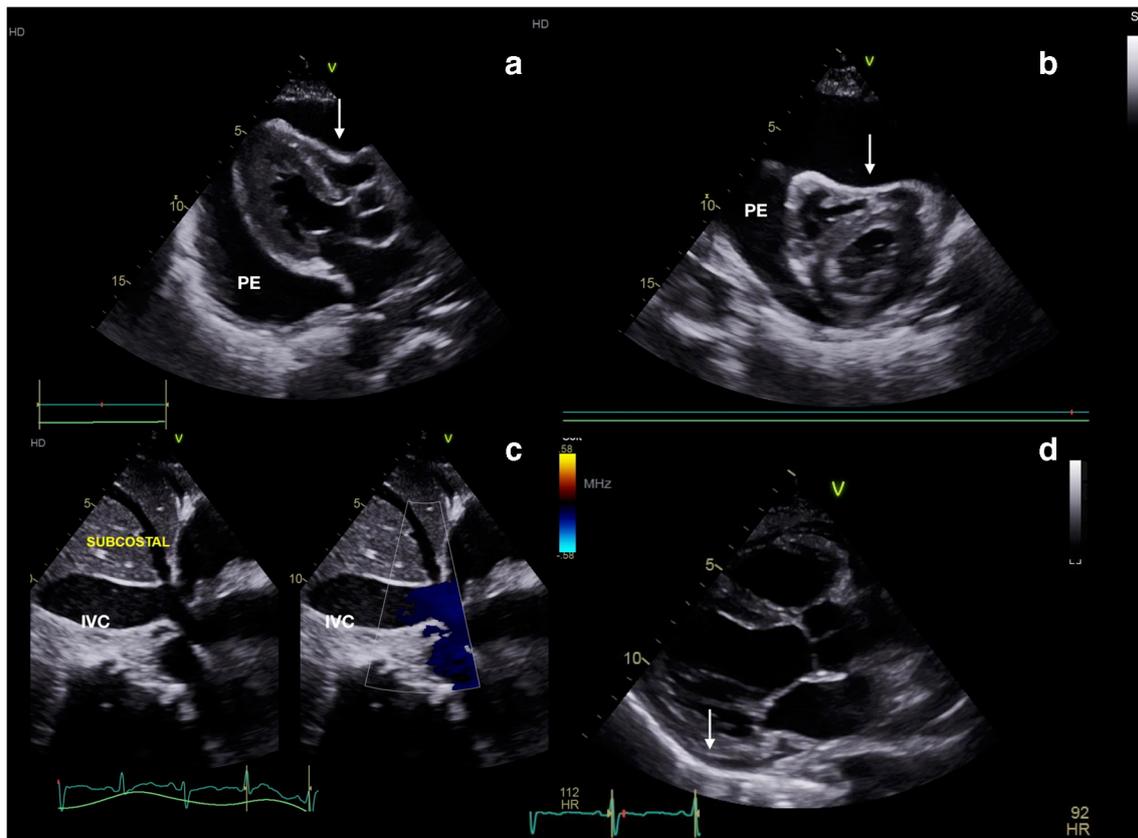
a Apical four-chamber view on 2D echocardiography with large circumferential pericardial effusion (PE) and right ventricular chamber collapse (*arrow*). b Parasternal short-axis view on 2D echocardiogram with right ventricular chamber collapse (*arrow*). c Plethoric IVC seen on
